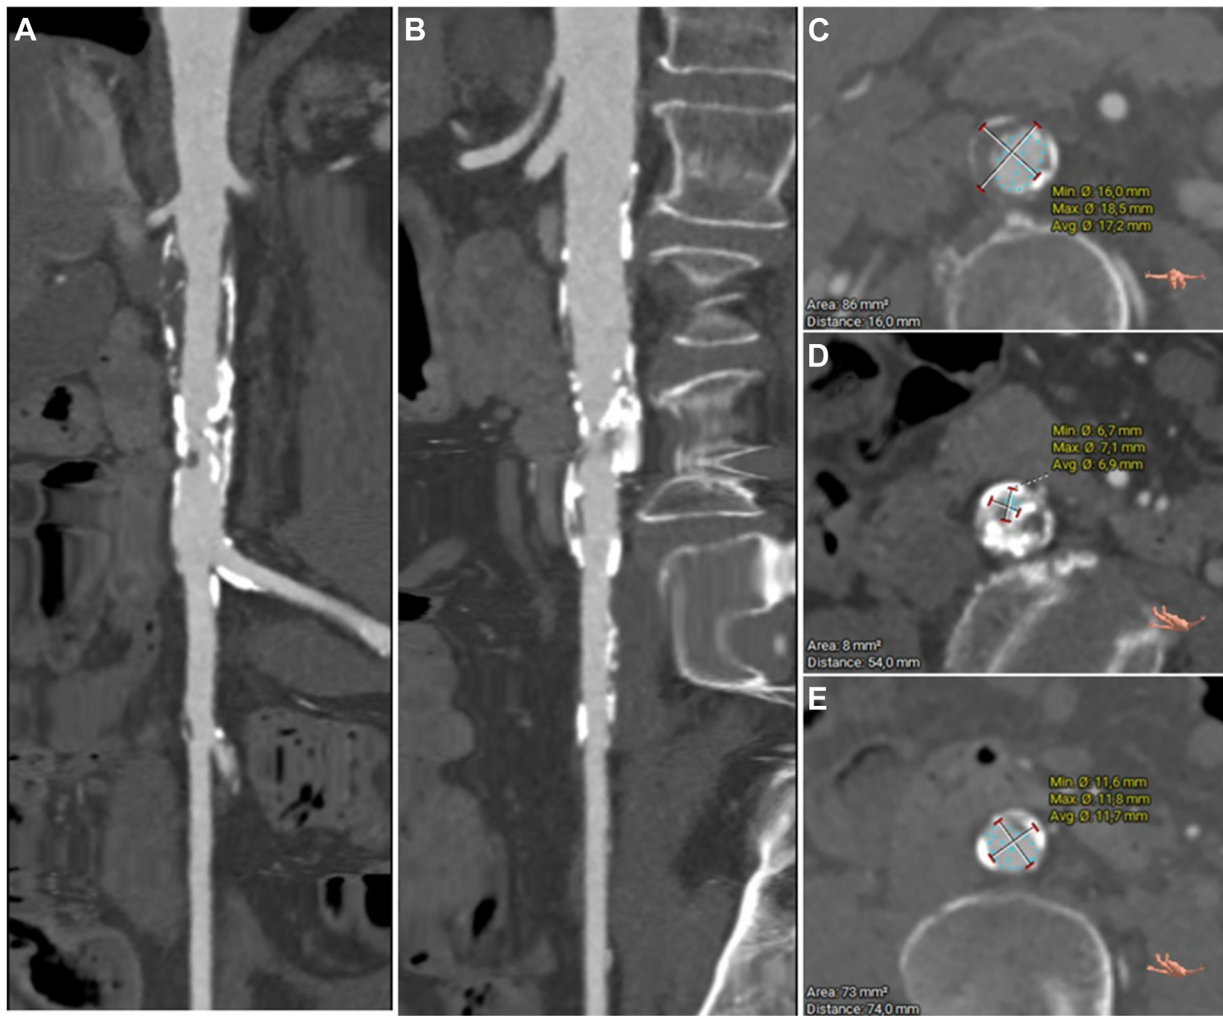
Centerline reconstruction of preoperative computed tomography angiography (CTA) reveals a calcified infrarenal aorta in both the anteroposterior (A) and lateral (B) views. Transverse sections provide detailed visualization of the aortic lumen before (C) and at the site of stenosis (D), followed by the poststenotic segment (E).
